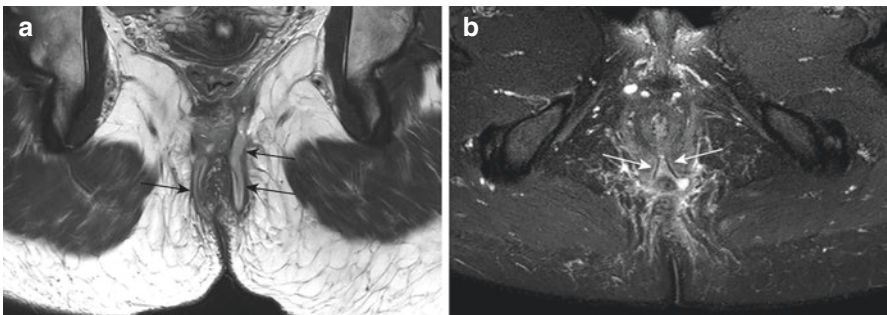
Transsphincteric fistula tracts (arrows) with setons (hypointense lines in the tracts on a coronal T2-weighted sequence (a) and fat-suppressed axial oblique T2-weighted sequence (b)
